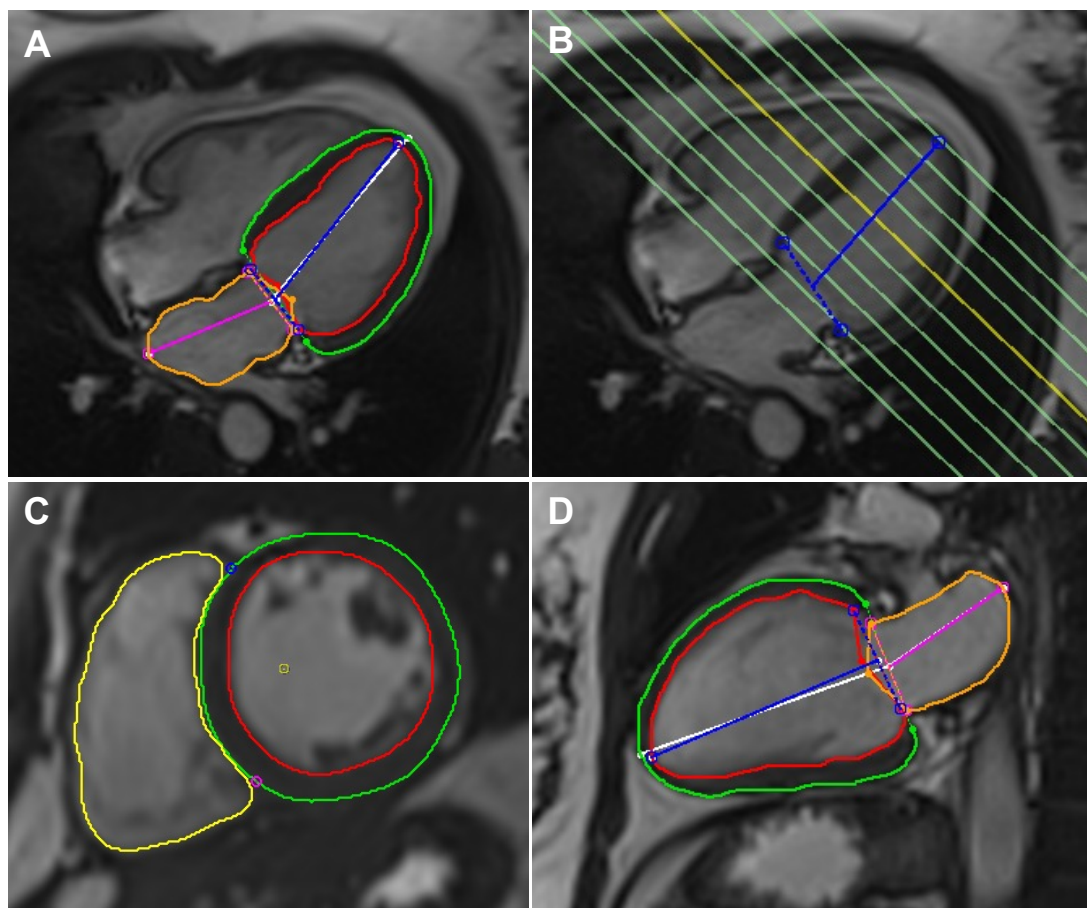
Representative cardiac H-MR images in the (A) horizontal long axis (B) locations of short axis images, (C) short axis, and (D) vertical long axis.
